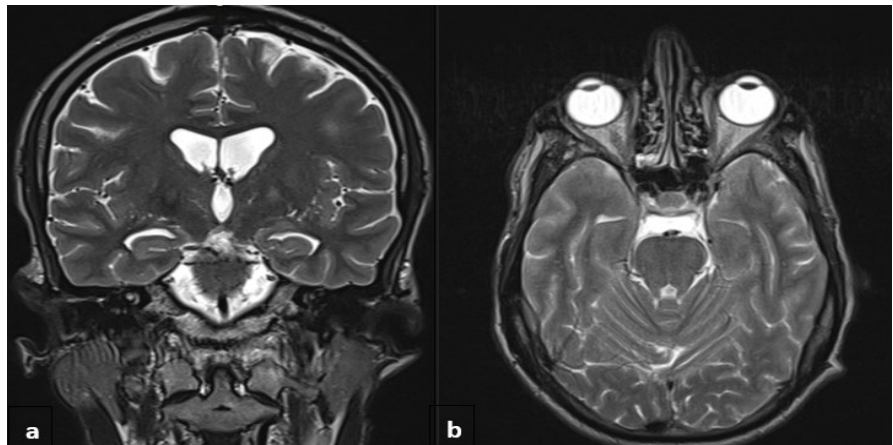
Brain MRI, T2-weighted sequence. (a) Coronal view (2.3 mm thickness) showing subtle hyperintensity in the midline perimesencephalic region. (b) Axial view (4 mm thickness) where no evidence of perimesencephalic hemorrhage is visible.
